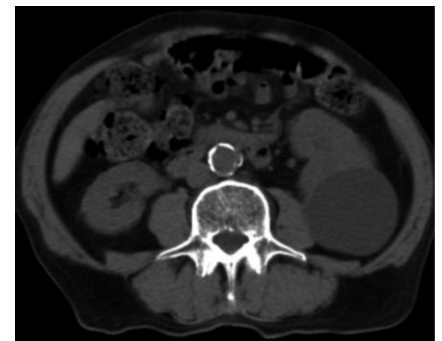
Abdominal computed tomography showing a heterogeneous lesion in the upper pole of the right kidney, measuring 4.2×3.9 cm.
